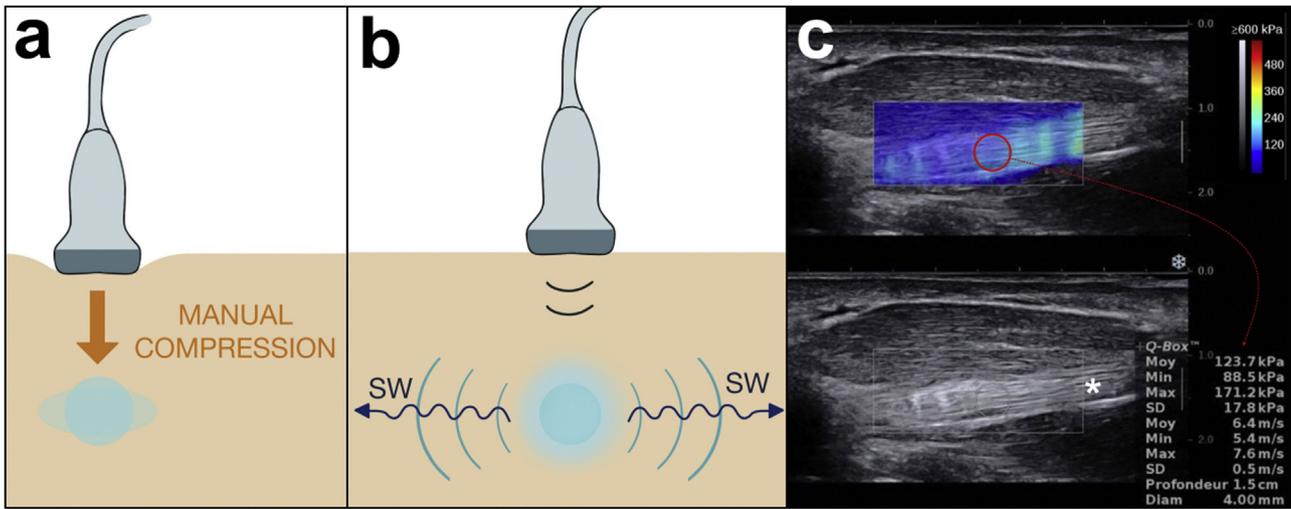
Ultrasound elastography: strain elastography (a) and shear wave elastography (b). The colored region represents the 2D quantitative elastogram superimposed on a B-mode image with a color scale (see top right). The software allowed us to measure the mean stiffness (Young’s modulus, in kPa) value and the shear wave velocity ($\text{m}\cdot\text{s}^{-1}$) of the flexor pollicis longus (asterisk) inside a circular region of interest (ROI), (c).
